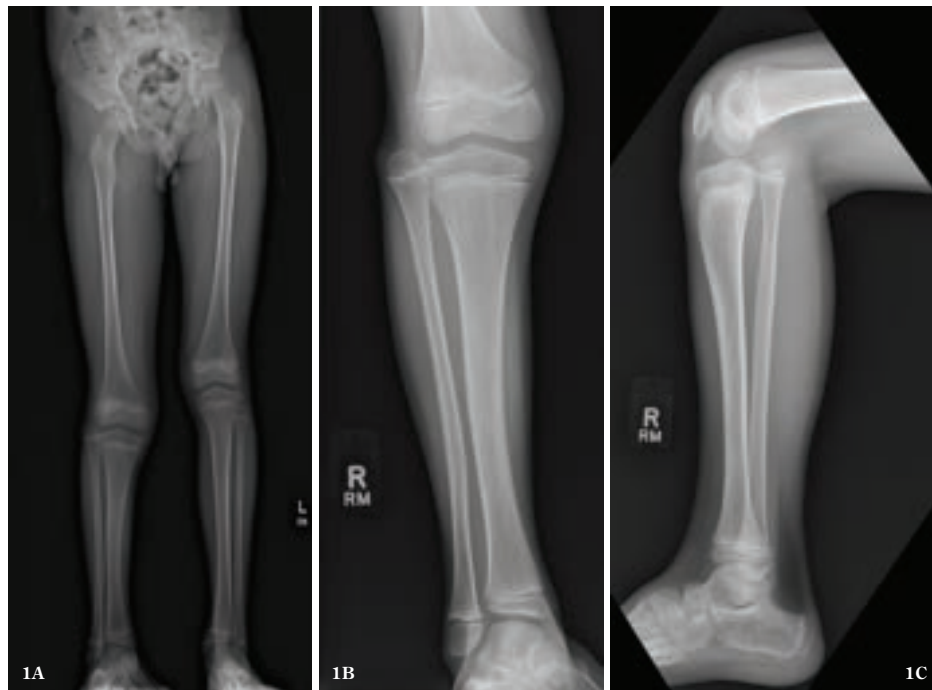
to 1C. 9 year 3 month old male with right tibial hemimelia. (1A) Anteroposterior (AP) standing radiograph of lower extremities showing a 4.7-centimeter leg length discrepancy with a predicted leg length discrepancy at maturity to be approximately 7.5 centimeters. (1B and 1C) AP and lateral radiographs of the right tibia/fibula prior to surgery.
